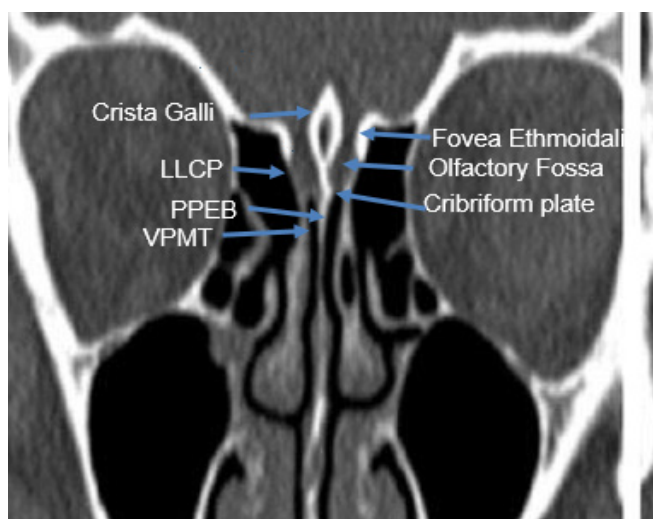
The different anatomical structures of the ethmoid roof and olfactory fossa in coronal view CT scan. CG-crista galli, OF-olfactory fossa, FE-fovea ethmoidalis, LLCP-lateral lamella of the cribriform plate, PPEB-perpendicular plate of ethmoid bone, VPMT-vertical plate of middle turbinate⁵
